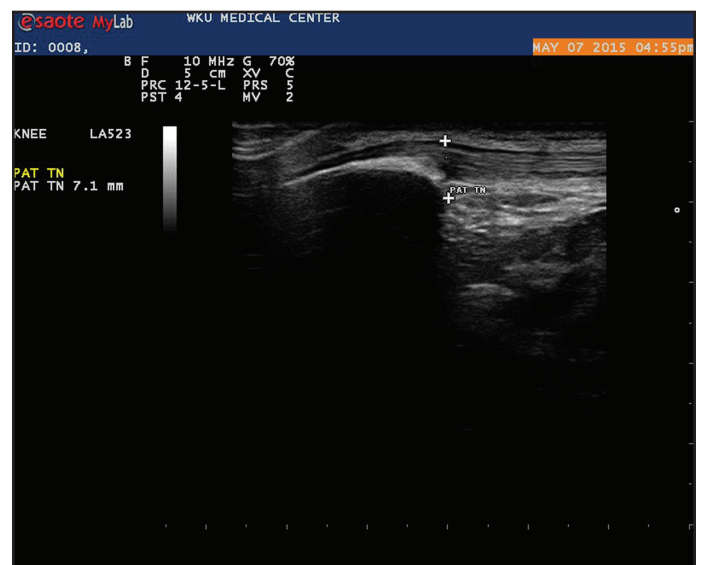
Ultrasound image of the post-measured inferior pole of the patella.
